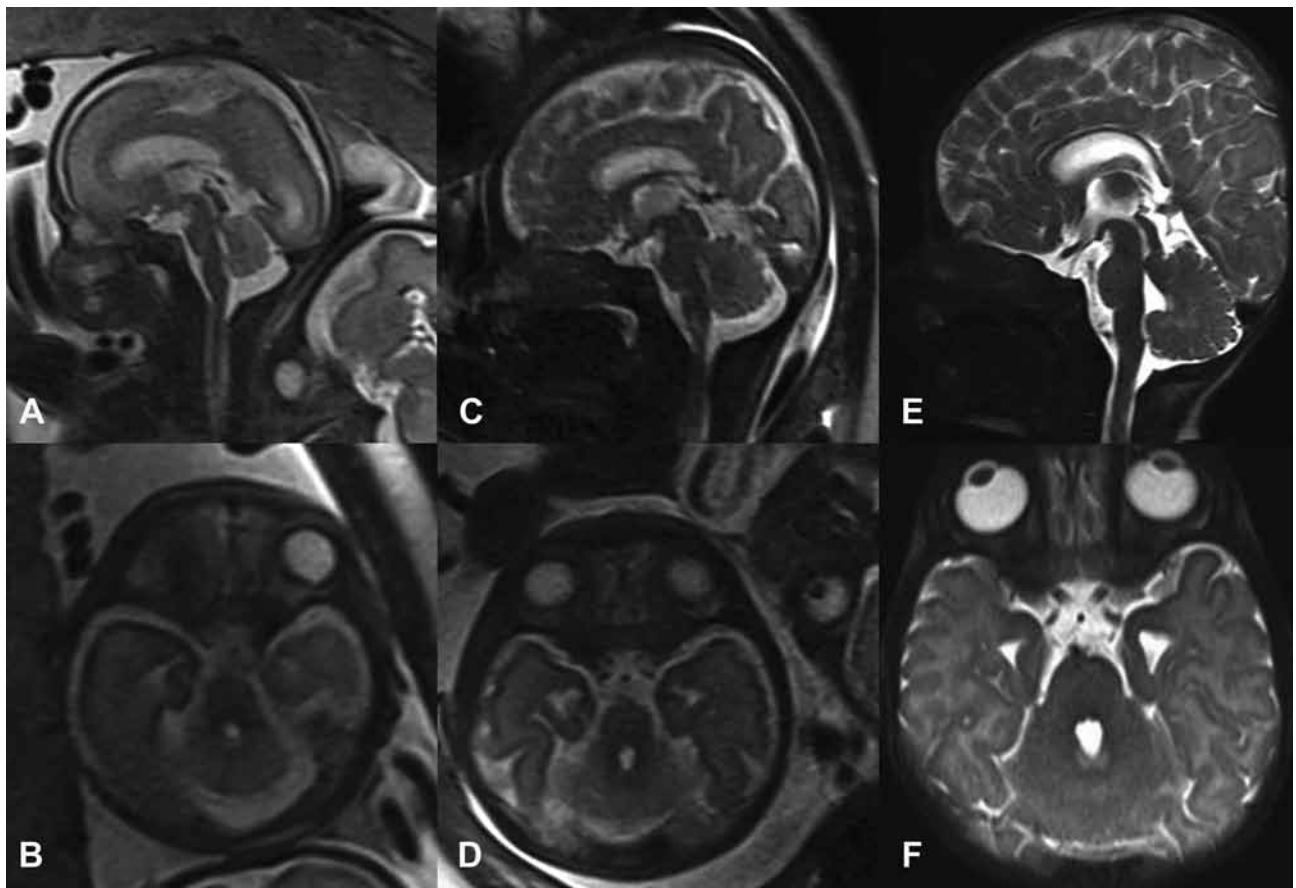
Partial rhombencephalosynapsis. Prenatal and postnatal MR images. A and B. Sagittal (A) and axial (B) MRI T2W images obtained at 27 weeks of gestation show normal sized posterior fossa and fourth ventricle, with rounded fastigial point. The cerebellum is smaller than expected for this gestational age, with partially fused inferior portions of the hemispheres and dentate nuclei. Anterior vermis appears normally developed, while posterior vermis is deficient. In the sagittal plane, the primary fissure can be recognized; the secondary fissure is present, but tiny; C and D. Follow-up sagittal (C) and axial (D) MRI T2W images obtained at 32 weeks of gestation show significant cerebellar growth. Partial fusion of the cerebellar hemispheres and abnormal vermian folial pattern are more prominent. The vermian fissures are more pronounced, but still shallow, compared to the depth of the vermian fissure in the healthy, first twin (not shown); E and F. Postnatal, sagittal (E) and axial (F) T2-weighted images obtained at 3 months of age confirm the prenatally detected cerebellar and vermian pathology. Except for the slightly thinner corpus callosum, the remainder of the supratentorial brain exhibited none of the abnormalities, commonly found in association with the classical form of rhombencephalosynapsis.
